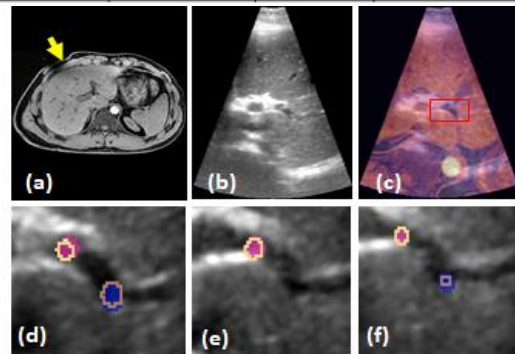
Hybrid deformable registration results. (a) & (b) are simultaneous MRI and US with yellow arrow showing the position of the US probe. Deformed MR on US after registration in (c). Zoomed views (within the red box of (c)) of deformed MR and US landmarks overlaid across temporal US volumes are shown in (d) – (f). Shaded regions are deformed MR landmarks, solid lines are reference US landmarks.
